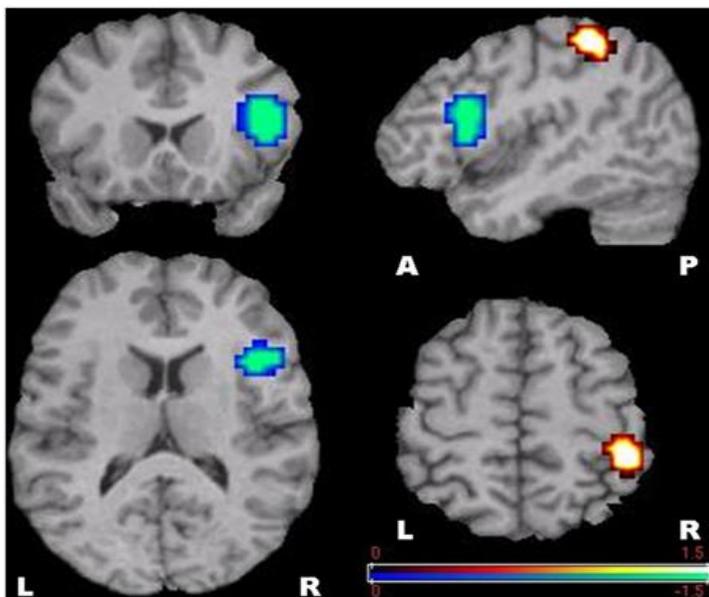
Gamma brain waves captured by MRI. It can be seen that mental synchronization is the presence in the right posterior parietal cortex, while asynchronization occurs in the lower right frontal gyrus (Ishii, 2014)
